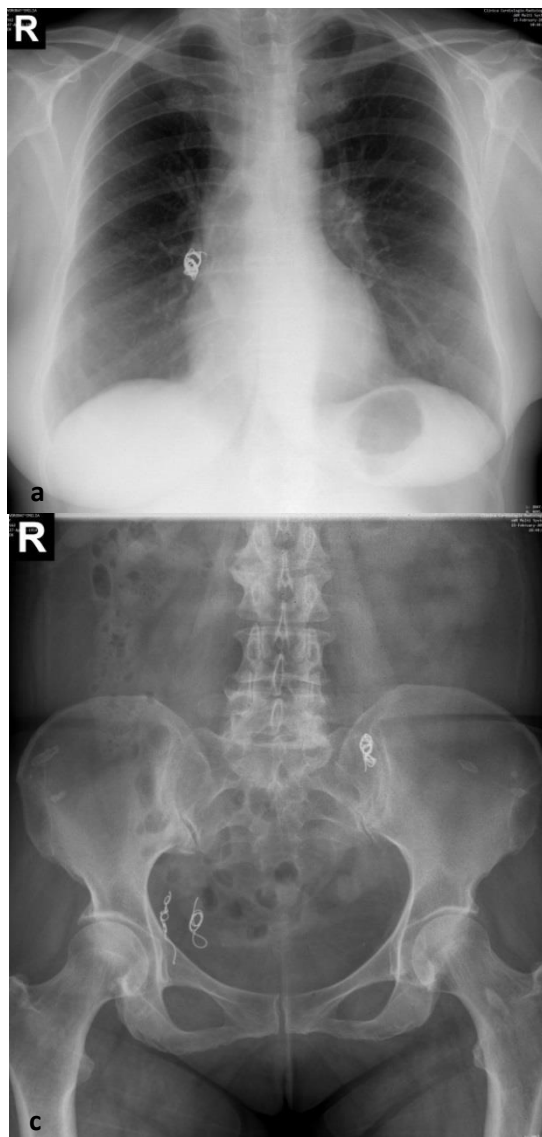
Chest X-ray: postero-anterior view (a) and lateral view (b) with the coil on the right hilum topography and pelvis X-ray (c) with the coils on the hypogastric and gonadal veins.
